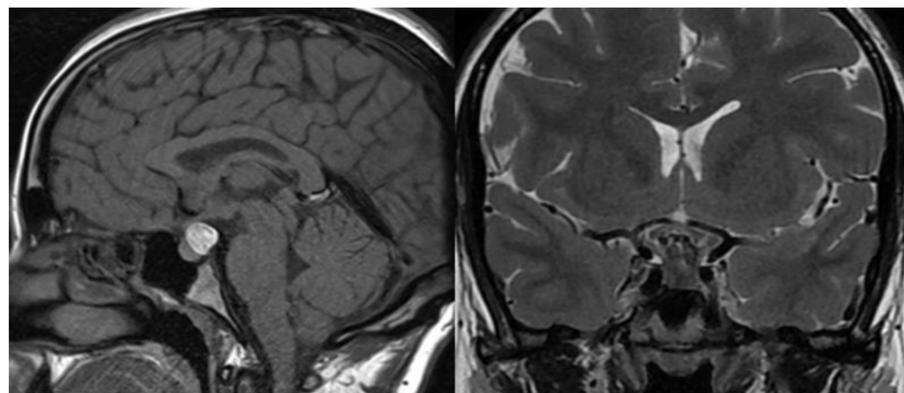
Third case - Preoperative brain MRI showing a lesion in the posterior sella region and suprasellar area, hyperintense on T1, without contrast enhancement, and areas of hypointensity and isointensity on T2.
